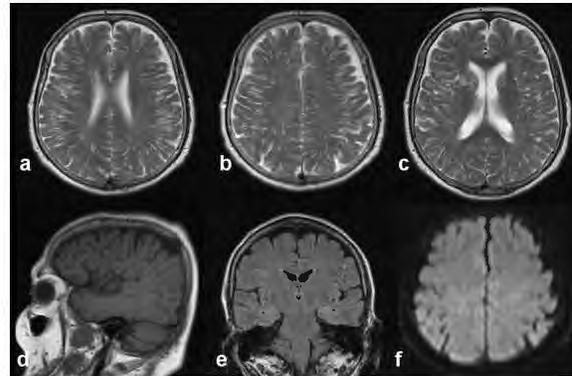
MRI images of a 67 year old female patient with progressive cognitive dysfunction are shown. Atypical PVS enlargements are seen diffusely along all tracts, causing longitudinal enlargement rather than cystic expansion.
